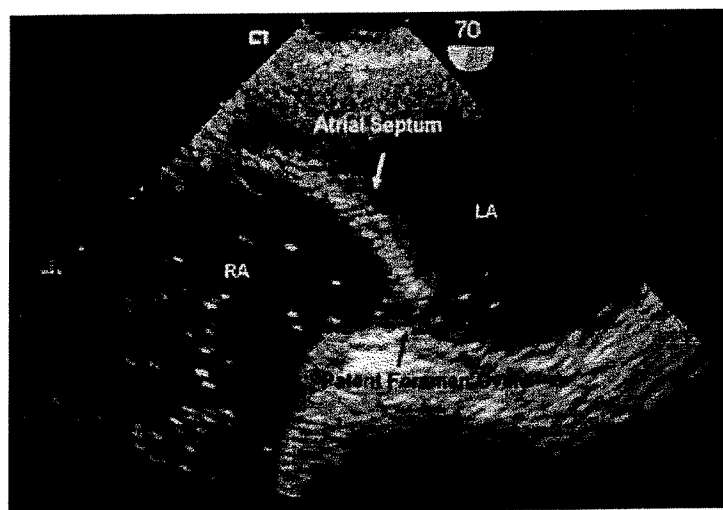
Bubble test. Transesophageal echocardiogram shows bubbles passing from right atrium to left atrium through patent foramen ovale (arrow). RA, Right atrium; LA, left atrium.
